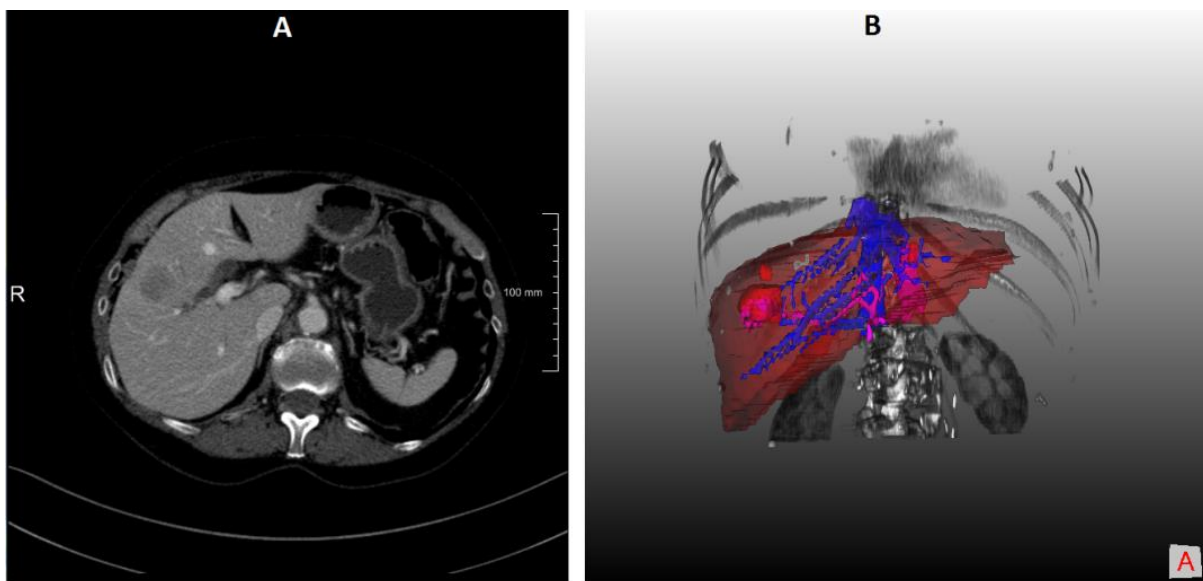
A typical contrast enhanced CT image of the liver (A) and the 3D segmentations of the liver, vessels and tumors (B). The volume rendering provides 3D visualization of the liver and the tumor in a RFA planning stage.
